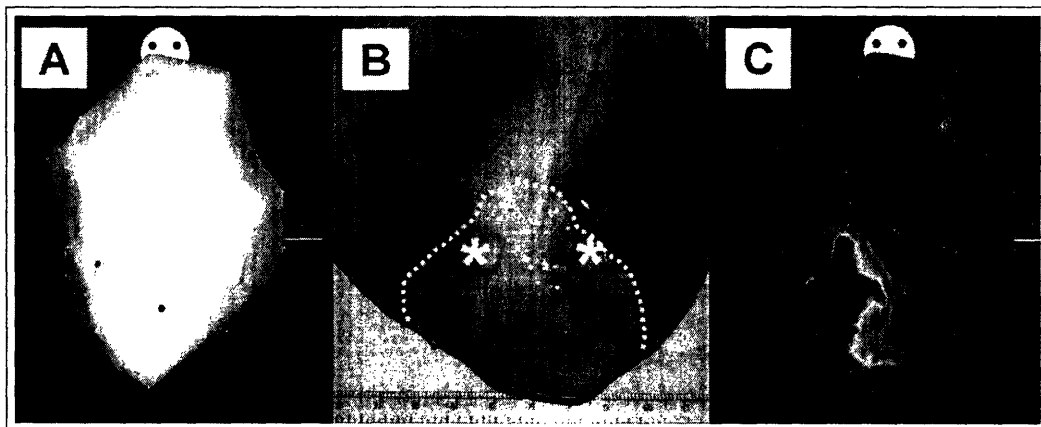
Epicardial ablation results. Using the registered ventricular epicardial construct, the ablation catheter was manipulated in the pericardial space to place lesions along the scar border. In A, the electroanatomical map is shown in an AP projection as a solid geometric shell without any annotated electrical information; the two red dots represent the locations of two ablation lesions delivered to the scar border (as defined by the registered MR image). In B, the ablation lesions (yellow asterisks) are indeed present at the scar border (dotted yellow line). In a C, the epicardial bipolar voltage amplitude map was displayed in a post-hoc fashion; the ablation lesions (red dots) were again situated at the scar border (as defined by a bipolar voltage amplitude of 1.5 mV).
